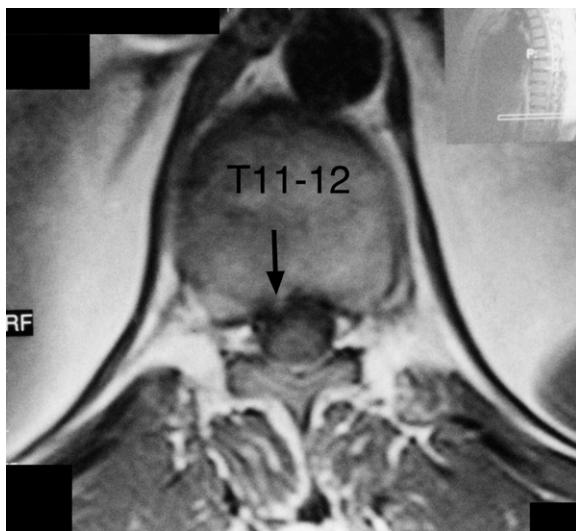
Thoracic spine MRI axial T1-weighted image at the T11–12 level. Note the right paracentral disc protrusion (arrow).
